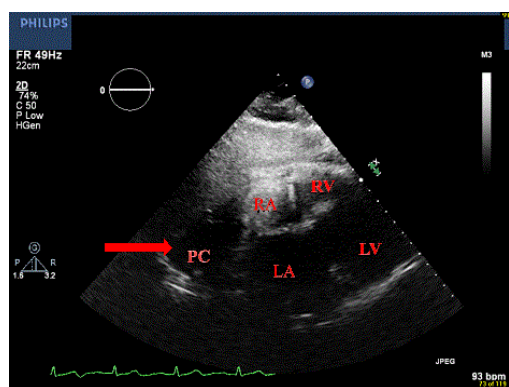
2D echocardiography with subcostal echocardiographic view using a contrast agent DEFINITY, which opacifies right atrium and right ventricle. However the pericardial cyst, which is adjacent to the right atrium, does not fill with contrast agent.
